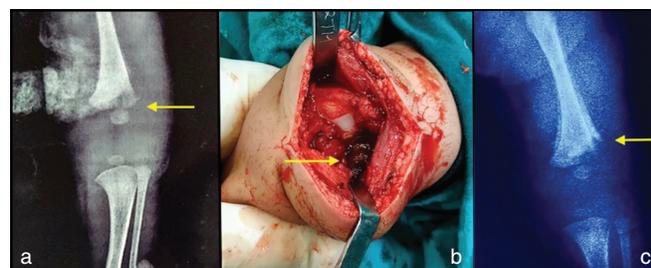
(a) Preoperative antero-posterior X-ray of the left knee showing a lucent zone (yellow arrow); (b) intraoperative image demonstrates an intact medial condyle and a deficient lateral femoral condyle (yellow arrow); (c) postoperative (10 days) antero-posterior X-ray showing the now absent lateral femoral condyle (yellow arrow)
